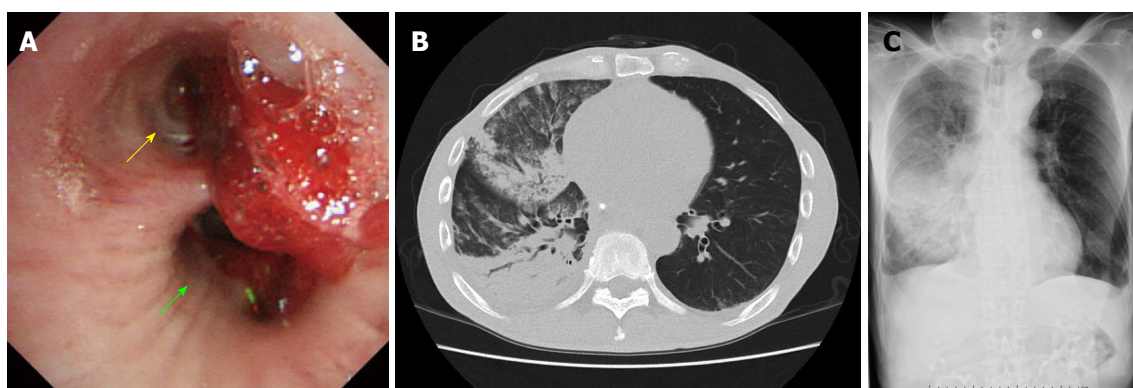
Imaging findings before bronchial arterial embolization. A: Bronchoscopy revealed hemoptysis in the entrance of the right middle lobe bronchus (yellow arrow) extending down to the lower lobe bronchus (green arrow); B, C: Computed tomography and chest radiography revealed a massive infiltrative shadow in the right middle lobe with atelectasis in the right lower lobe.
